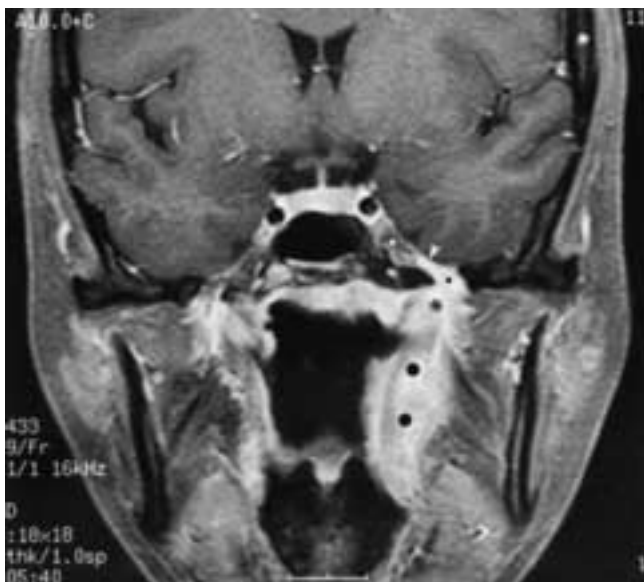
Nasopharyngeal carcinoma with lateral extension to the masticator space and mandibular nerve via PNS. Coronal contrast-enhanced, fat-suppressed T1-weighted image shows the left nasopharyngeal lesion (*large black dots*) with lateral extension to involve the upper masticator space (*asterisk*). Tumor is extending perineurally through the widened foramen ovale (*small black dot*). Although there is tumor in the most proximal aspect of the mandibular nerve (*arrowhead*), Meckel's cave (*white dot*) appears to be spared. (From Ginsberg LE. Imaging of perineural tumor spread in head and neck cancer. *Semin Ultrasound CT MR* 1999;2:175–186.)
